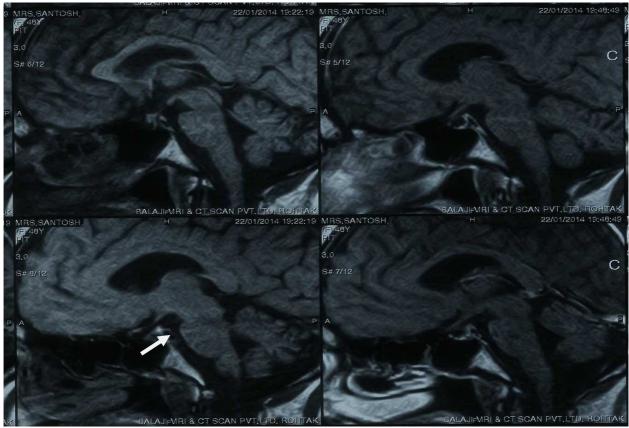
MRI Pituitary Showing Hypoplastic Pituitary
